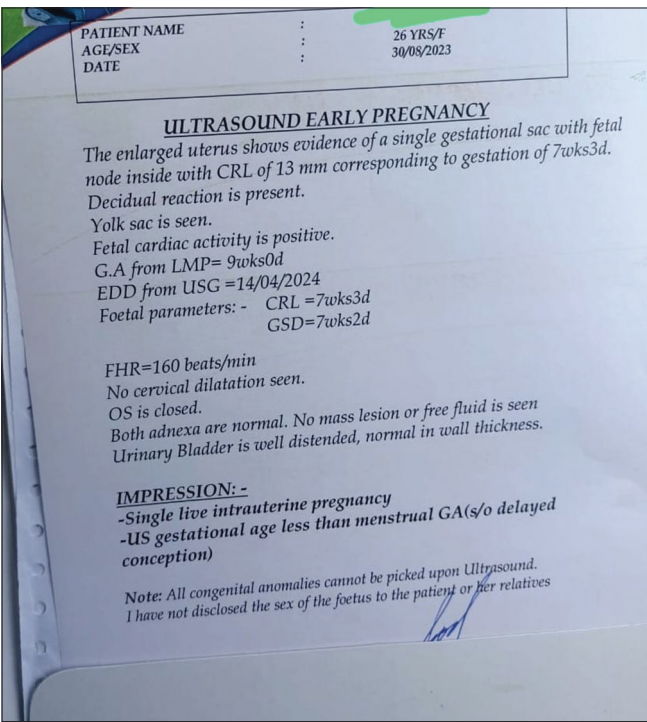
Sonography report after treatment
